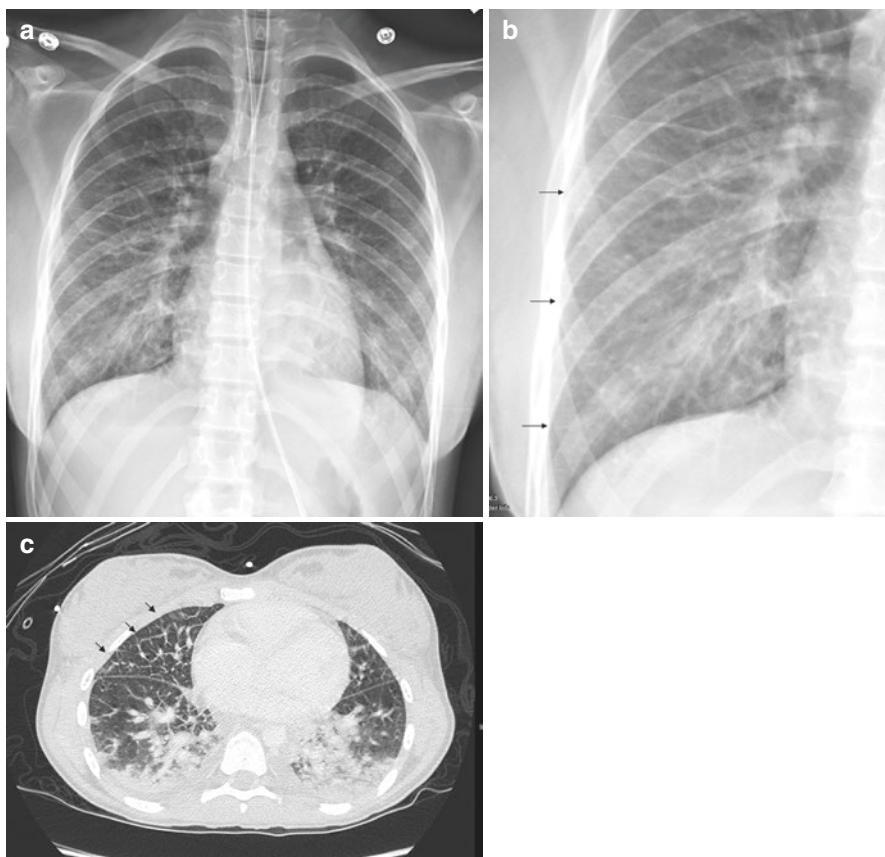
A 13-year-old female hospitalized in pediatric ICU with noncardiogenic (septic) shock. Frontal chest radiograph (a) and magnified view of the right lung base (b) demonstrate pulmonary interstitial edema with Kerley B lines (black arrows). Lung window image from chest CT (c) confirms interlobular septal thickening (black arrows); dependent atelectasis and small pleural effusions were also shown on soft tissue windows
